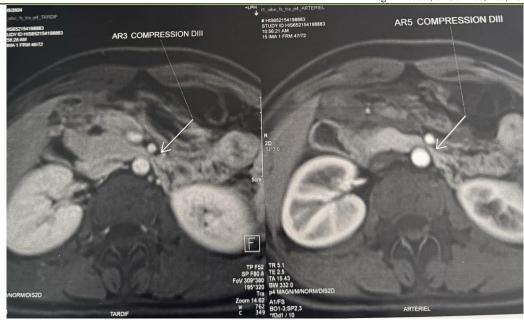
MRI biliary sequence showing compression of the third portion of the duodenum between the superior mesenteric artery and the aortovertebral plane
